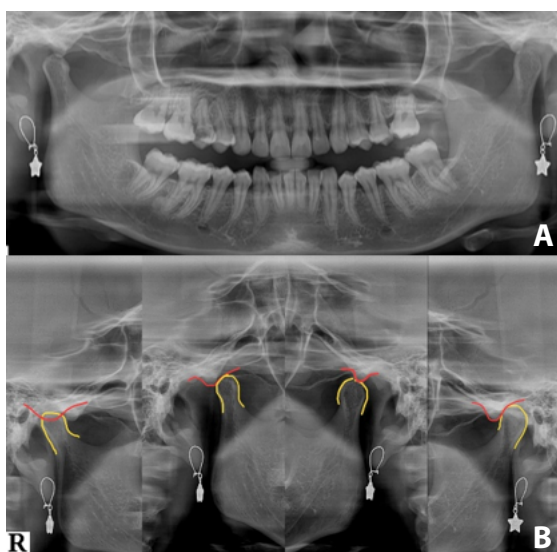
A. Panoramic radiograph, B. TMJ radiography
